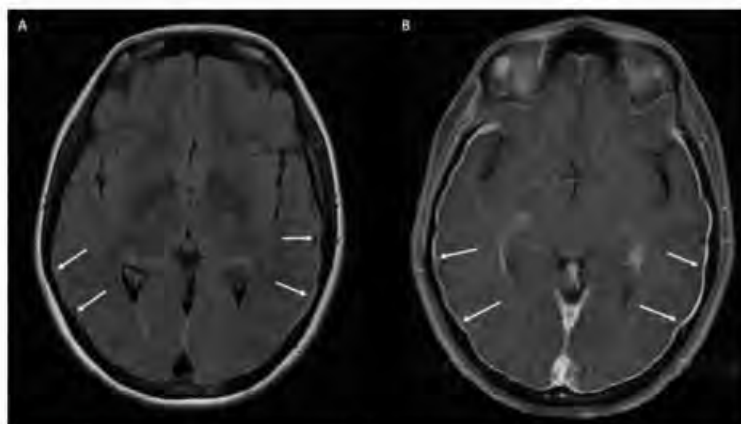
MRI brain imaging of a 41 year old female patient with symptoms of intracranial hypotension. A, axial non-contrast FLAIR sequence demonstrates diffuse pachymeningeal hyperintensity (arrows) and B, axial T1 post-contrast, shows diffuse pachymeningeal enhancement (arrows).
